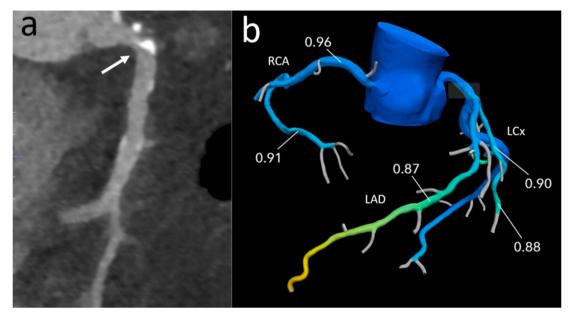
Case of a 71 year old female with exertional chest pain. a. Coronary CTA: eccentric partially calcified plaque in the right coronary artery causing moderate stenosis. b. Fractional flow reserve CT shows that the RCA stenosis is hemodynamically insignificant with a CT FFR value of 0.96 distal to the lesion. Final score CAD-RADS 3/P2/I-.
